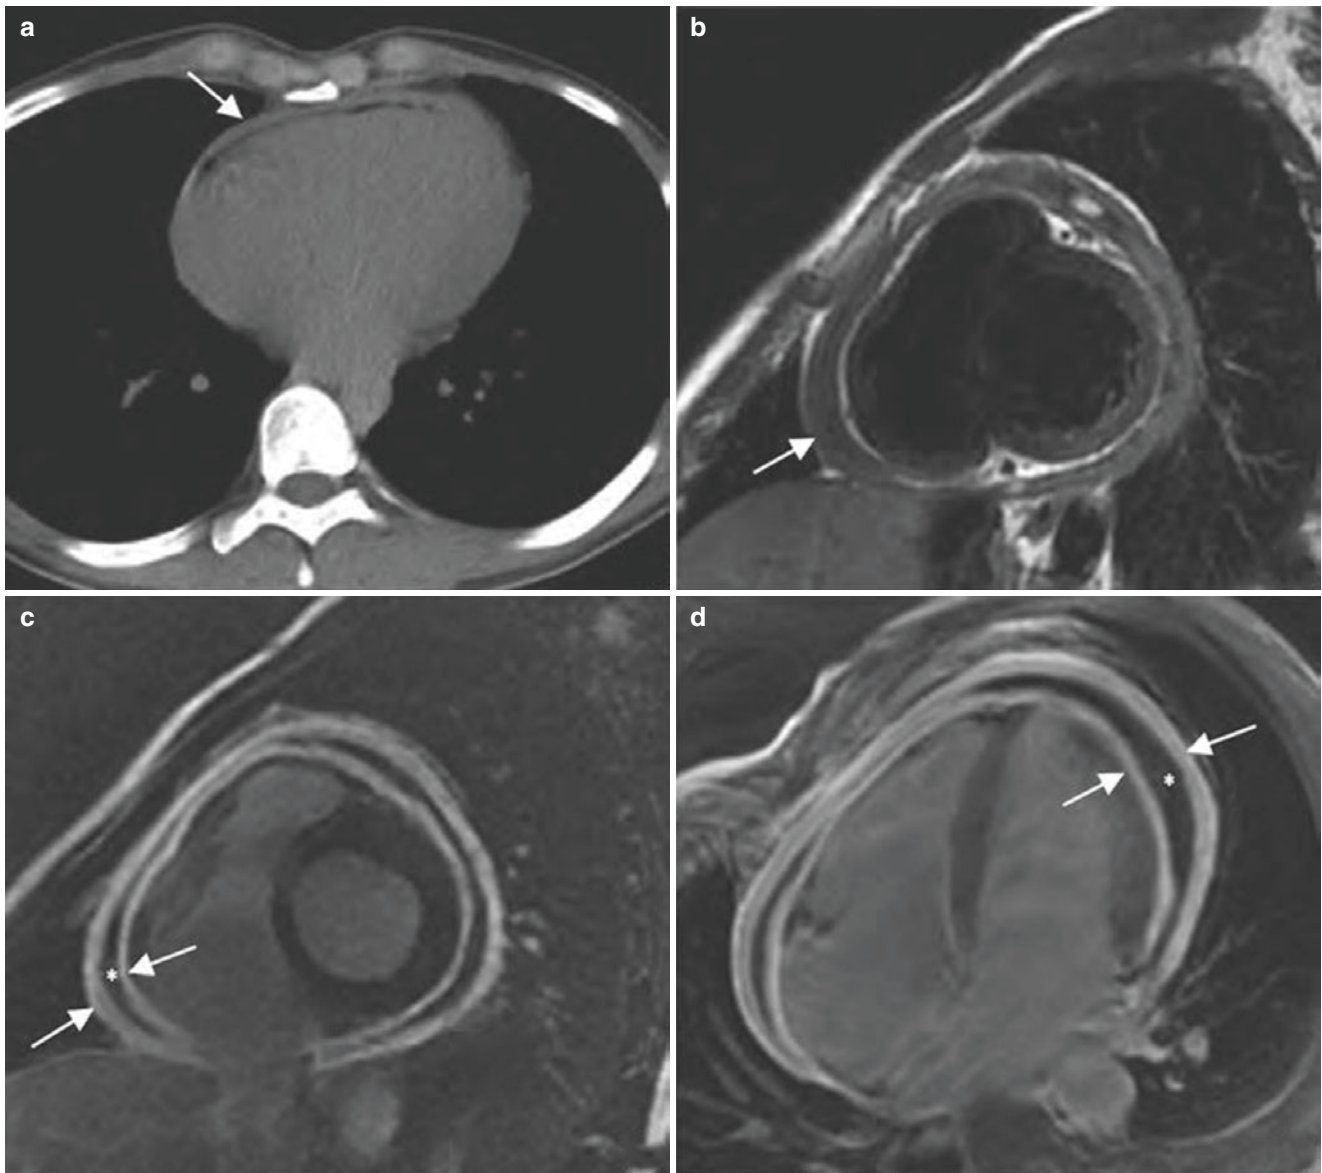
Acute pericarditis. (a) CT plain scan showed diffuse pericardial thickening (arrow), which was limited by imaging conditions, and a small amount of pericardial effusion was not clearly displayed on CT; (b) cardiac MRI plain scan (black-blood technique) clearly showed diffuse pericardial thickening (arrow), and stripe-like hyperintensities on
